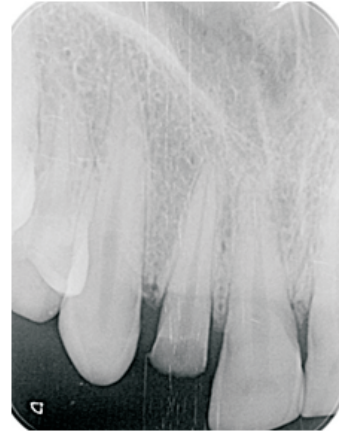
Pre-operative I.O.P.A. radiograph
